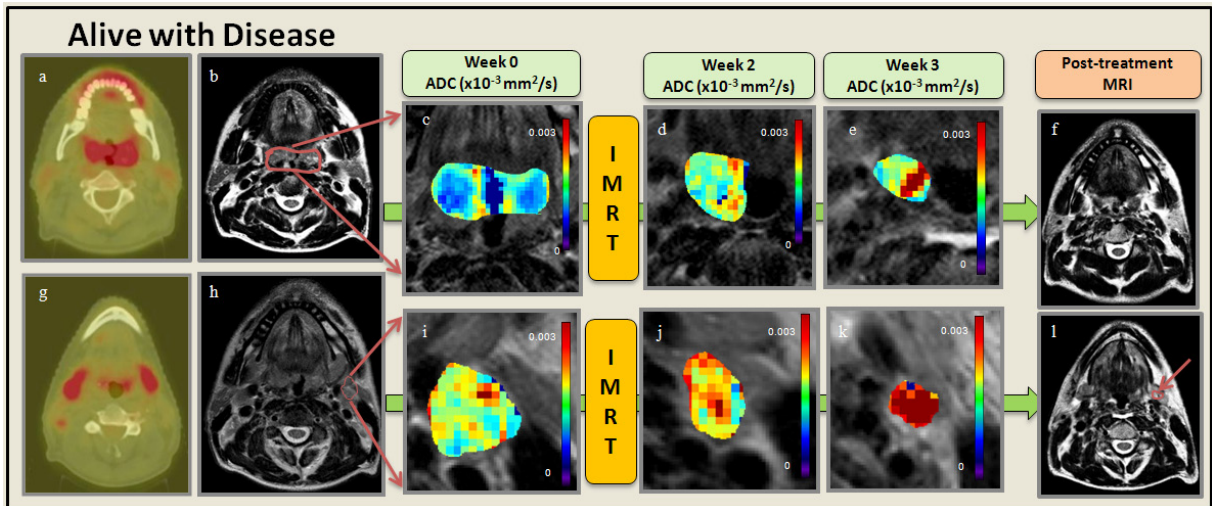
Representative AWD patient. a. and g. pre-Tx PET/CT of the primary tumor and two neck nodal metastases. b. and h. Primary tumor and representative neck nodal metastasis contoured over a T2W MRI. c. and i. pre-Tx ADC map overlaid on T2W MRI. d. and j. Wk2-Tx ADC map overlaid on T2W. e. and k. Wk3-Tx ADC map overlaid on T2W. f. and l. T2W MRI post-Tx with no evidence of primary tumor but with presence of neck nodal metastasis.
